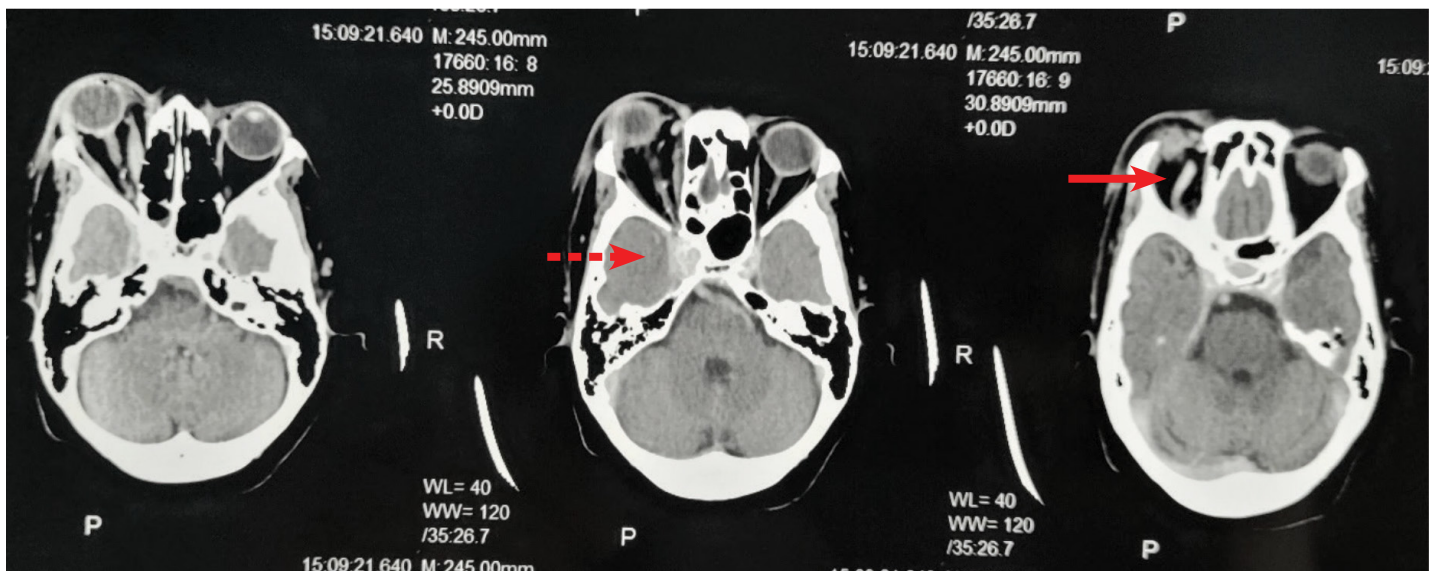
Contrast CT Brain showing right globe proptosis, enhancement and enlargement of medial rectus muscle, a prominently dilated right superior ophthalmic vein (arrow) and fullness of the right cavernous sinus (dashed arrow).
